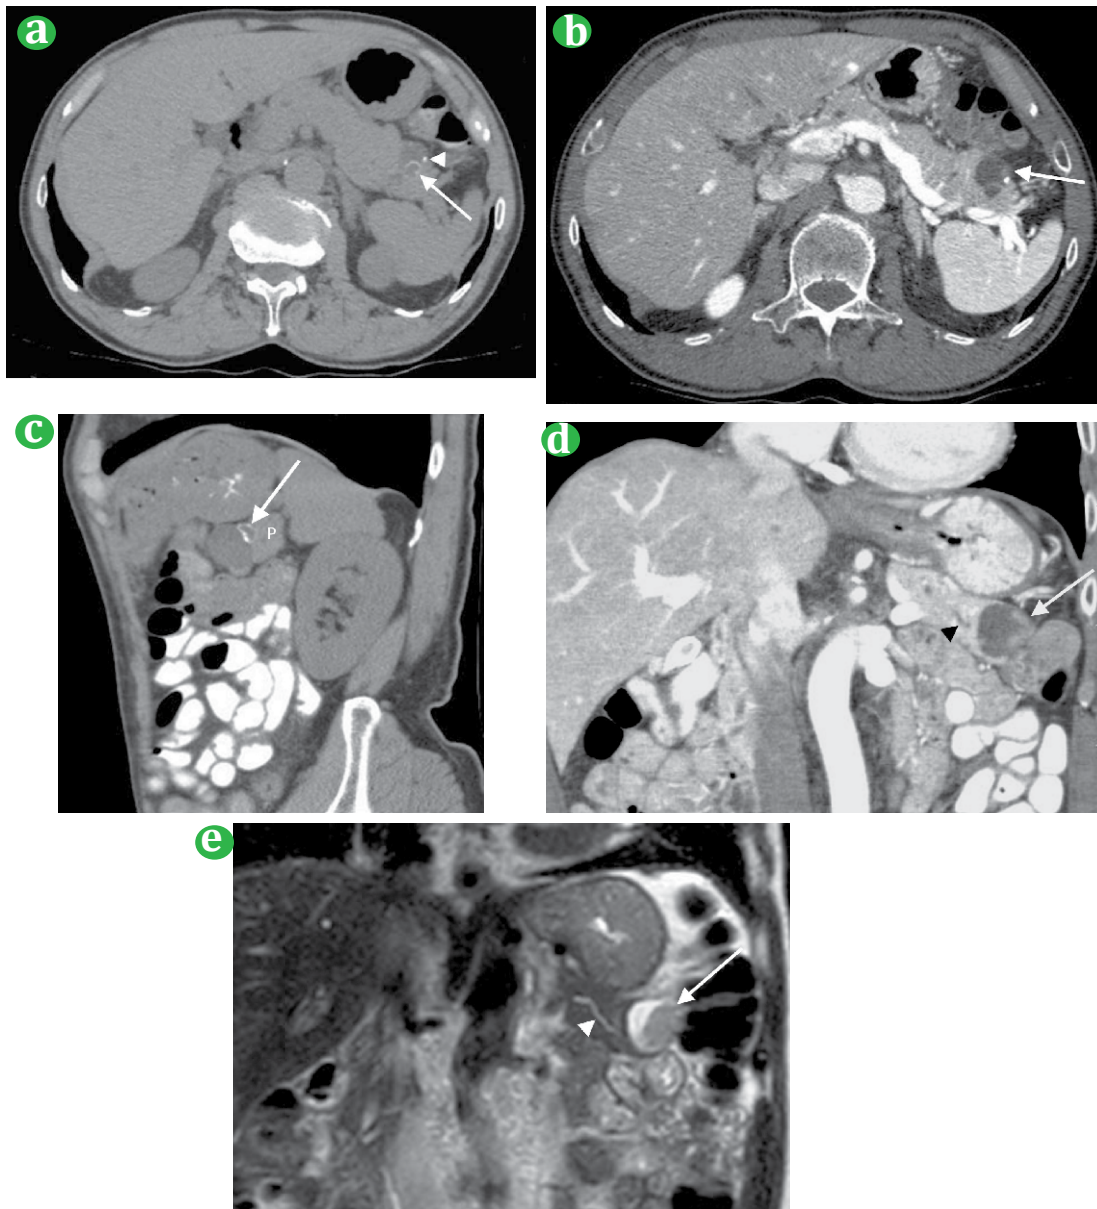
(a). Axial unenhanced CT scan shows the fluid density cystic lesion in the pancreatic tail with an area of egg-shell calcification (arrow). There is a separate focus of calcification (arrowhead) which corresponded to the dystrophic calcification within the tubule-papillary adenoma. (b). Axial contrast enhanced image at the same level depicts the enhancing adenoma (arrow). (c). Sagittal unenhanced image provides better detail of the eggshell calcification (arrow) within the lesion arising exophytically off the tail of the pancreas (P). (d). Coronal enhanced CT scan shows optimally the enhancing adenoma (arrow) and a normal pancreatic duct (arrowhead). (e). Coronal T2 Weighted MRI demonstrates the cystic nature of the mass with solid components (arrow) and a normal pancreatic duct downstream (arrowhead).
